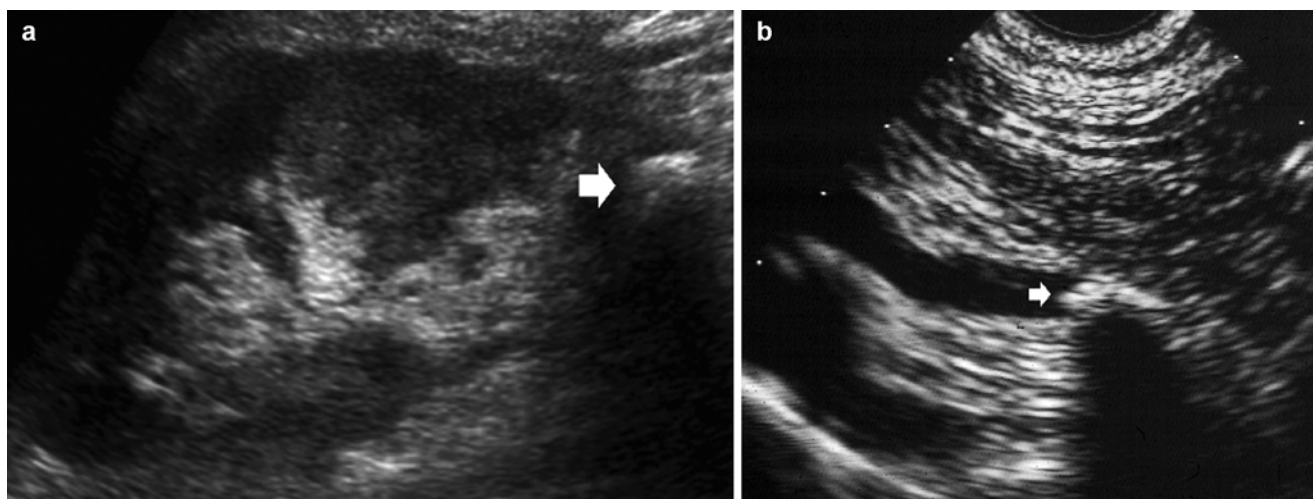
(a) Greyscale ultrasound. Longitudinal scan. A calculus (*arrow*) with posterior acoustic shadowing is visualised in the lower pole of the left kidney. (b) Greyscale ultrasound. Longitudinal scan. A calculus (*arrow*) with posterior acoustic shadowing is visualised in the distal ureter
